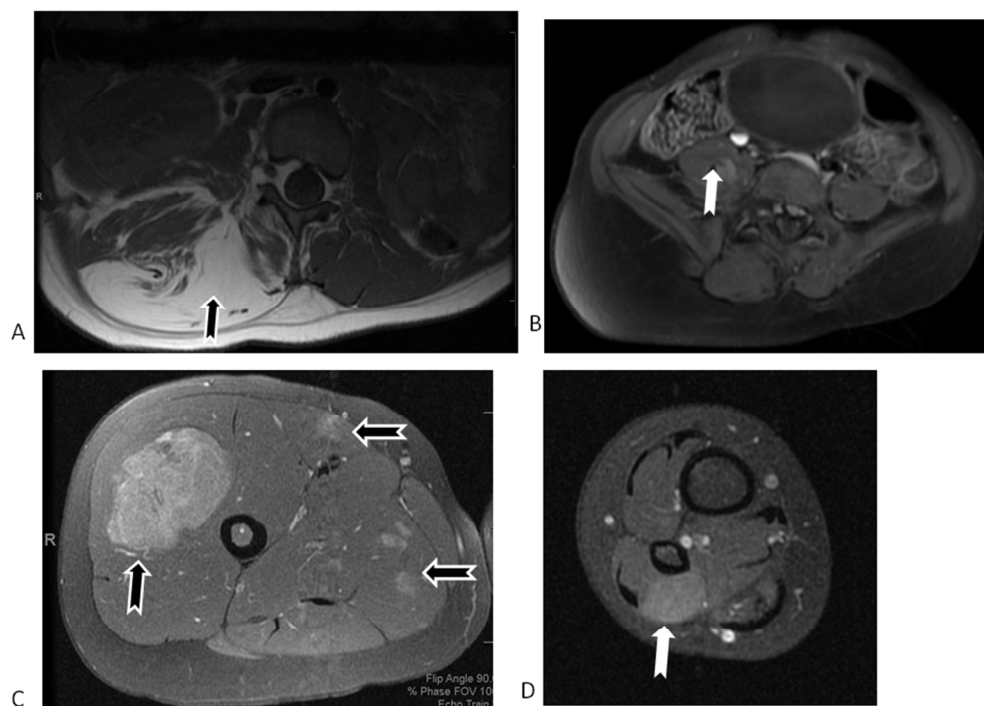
Patient 1's MRI obtained at age 7 years showed (A) a prominent right paraspinal fatty mass involving erector spinae musculature with anterior displacement of the right L3 exiting nerve root implying fat infiltration into the right L3-L4 neural foramen; increased diameter of the right psoas, thigh and calf musculature compared to the left (not shown) with enhancing lesions in the right psoas (B), vastus lateralis and medial right thigh musculature (C), and in the peroneus brevis (D).
